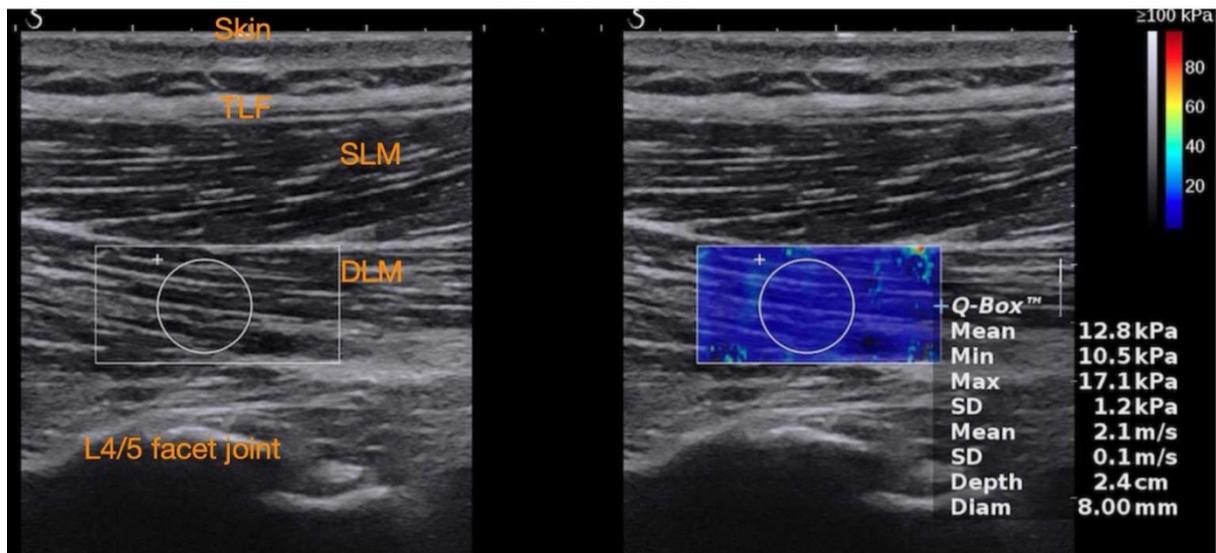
2 The locations and ultrasound shear wave elastography measurement of the deep (DLM) and superficial (SLM) lumbar multifidus with L4/5 facet joint as reference
